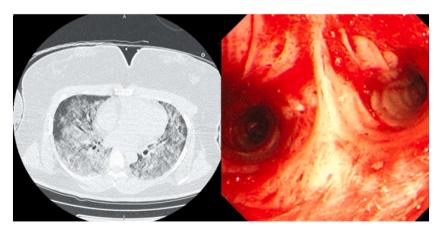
Non-contrast CT of the lung shows diffuse ground glass shadow and bronchoscope shows diffuse alveolar hemorrhage.
